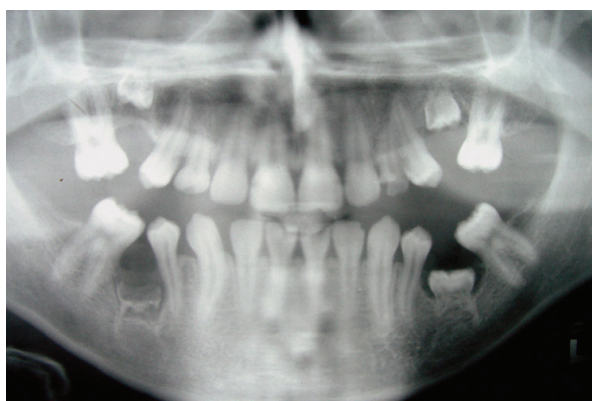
The panoramic radiograph of Twin HDH.
